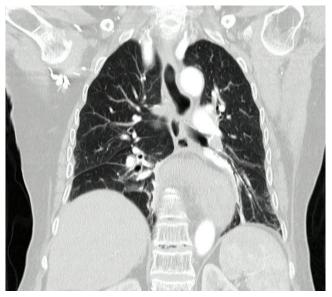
Contrast-enhanced CT scan: hernia of the gastroesophageal junction, fundus and antropyloric region towards the thorax and rotation of the stomach in its long axis.
